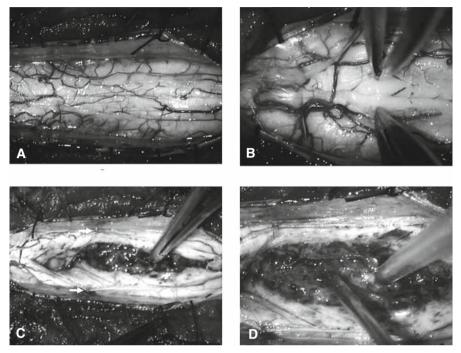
C2 ependymoma. Surgical sequences. A Localization of the midline. B Separation of both posterior columns with forceps. C Pial sutures to dura to keep open the surgical room. D Debulking with ultrasonic aspirator
